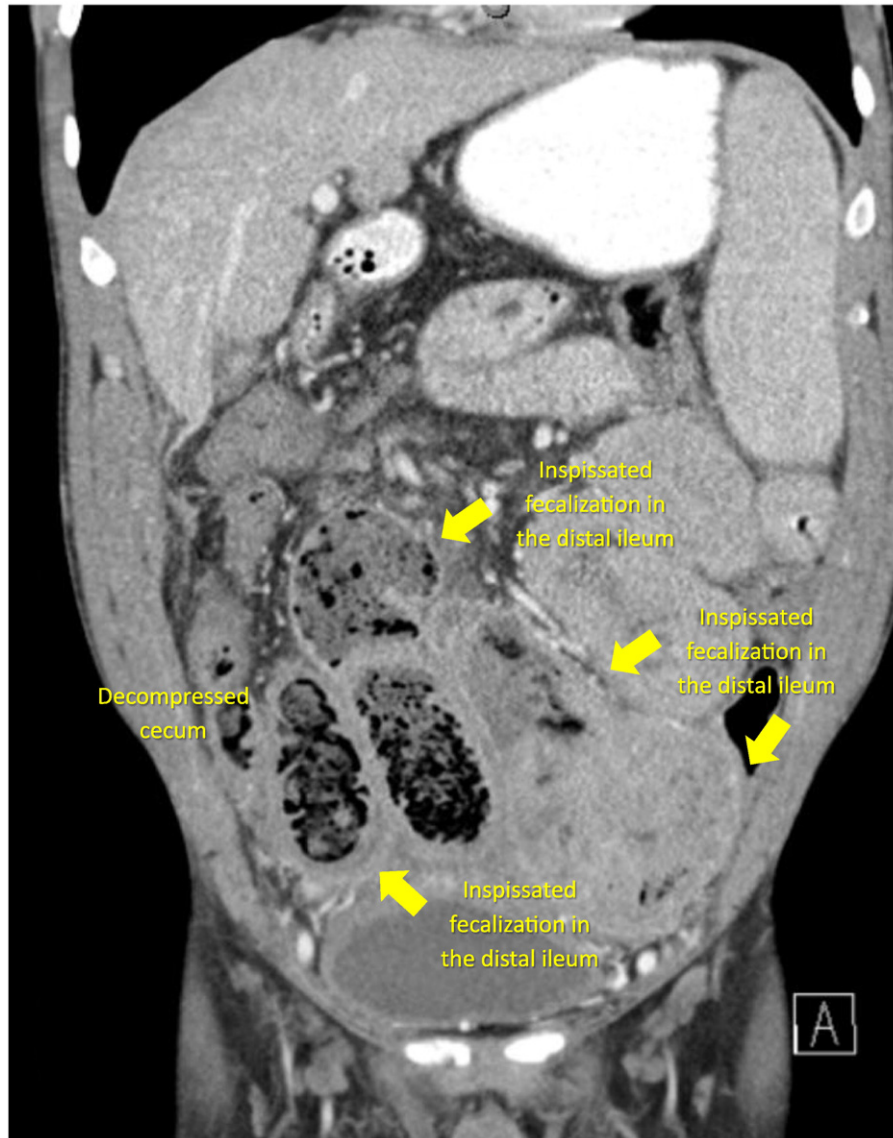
Recurrent DIOS in an adult patient with CF. Characterized by inspissated fecalization within the distal ileum with a decompressed cecum on CT scan (though the proximal right colon may also be involved in some cases), extending proximally into the small bowel with associated small bowel dilation. (denoted by arrows). Image courtesy of James M. Abraham, MD (University of Minnesota, Minneapolis, MN, USA).
